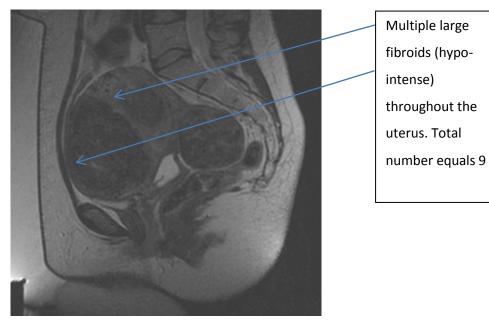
Category 3b Fibroid Uterus on sagittal T2 MRI
